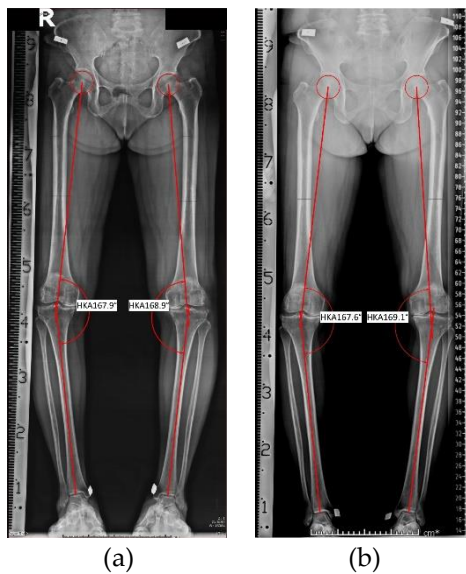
Orthoroentgenography/LLSR created by (a) RAPTOR and (b) standard X-ray generator. LLSR, long leg standing radiography; RAPTOR, Rapid Orthoroentgenography Making Machine.
